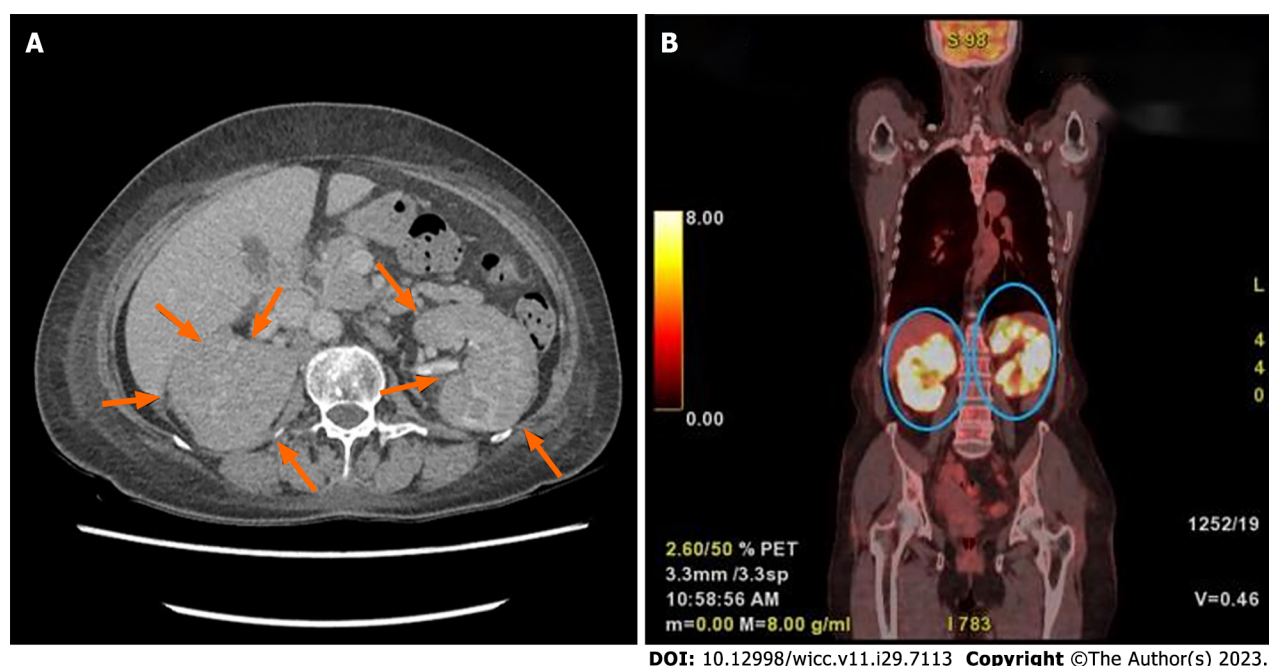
Radiologic findings. A: Abdominal computed tomography (CT) examination revealed diffuse homogeneous enhancement in both kidneys without definite visible cortico-medullary differentiation and was diagnosed as lymphomatous involvement; B: On fluorodeoxyglucose-positron emission tomography CT, intense hypermetabolism was also identified in both kidneys.
